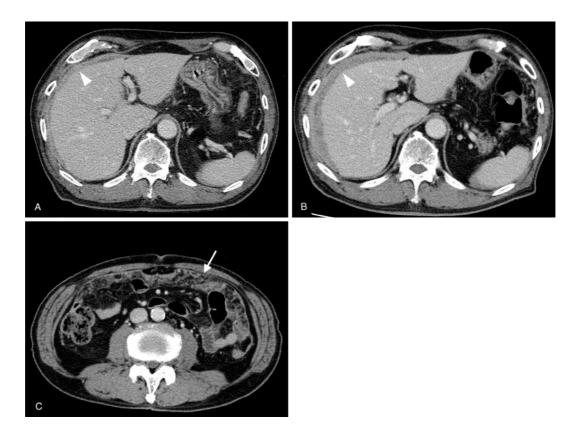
A) Intravenous contrast-enhanced CT scans show thickening of the anterior peritoneum in June 2020 (arrowhead). B) CT scans in August 2020 show exacerbation of peritoneal thickening (arrowhead). C) CT scans of the abdomen show omental cake (arrow).
